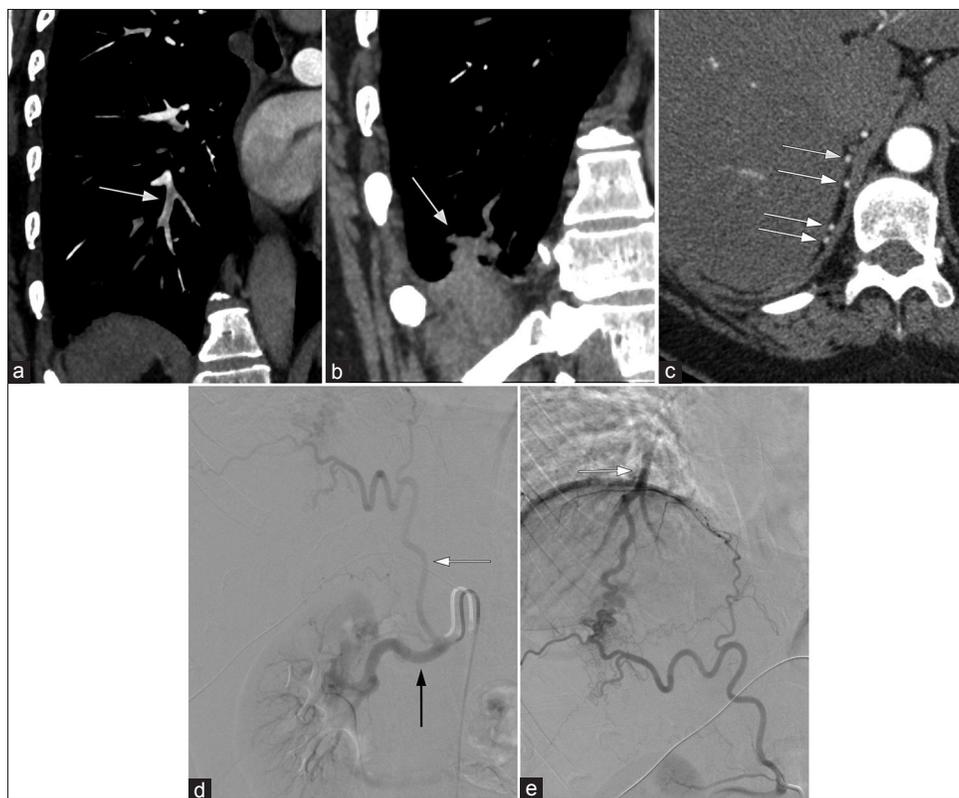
(a) A 59-year-old female with a history of non-ischemic dilated cardiomyopathy and symptoms of dyspnea diagnosed with pulmonary embolus on computed tomography angiography (CTA) 2 years prior. CTA coronal oblique reconstruction demonstrates an isolated linear defect in the right lower lobe pulmonary artery (white arrow). (b) Computed tomography (CT) angiogram demonstrates a hypertrophied arterial structure in the right lung base consistent with a vascular abnormality (white arrow). (c) CT angiogram demonstrates serpiginous hypertrophied arteries in the upper abdomen between the diaphragm and liver (white arrow). (d) AP digital subtraction right renal arteriogram demonstrates a hypertrophied right inferior phrenic artery (white arrow) originating from the right renal artery (black arrow). (e) Selective right inferior phrenic arteriogram demonstrates opacification of the inferior RLL pulmonary artery (white arrow).
